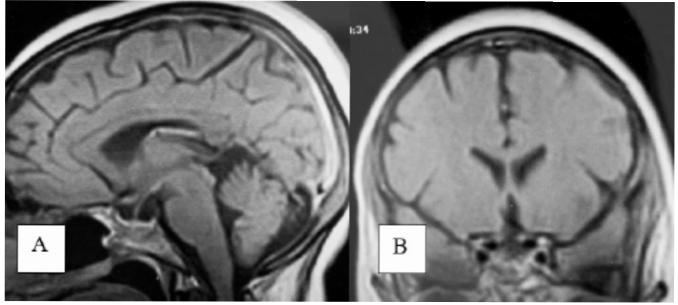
Sagittal (A) and coronal (B) MRI T1WI of the same patient three-month postoperatively.
